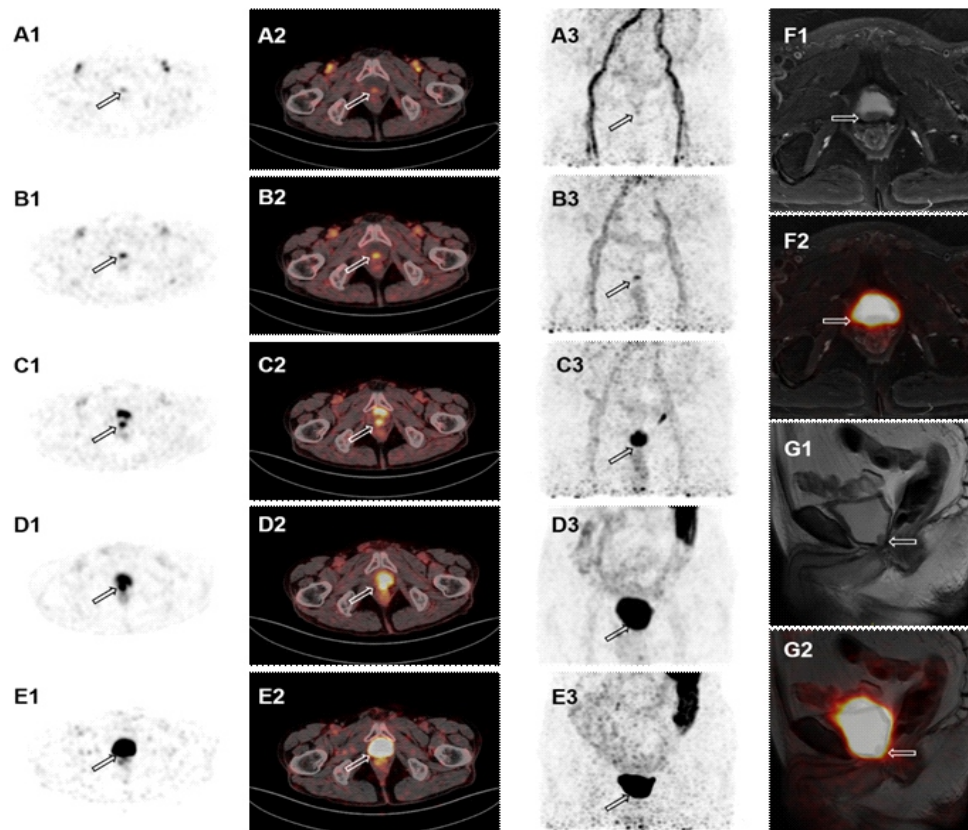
A 79-year-old man with prostate cancer was treated with prostatectomy. He presented with a rising PSA level of 6.00ng/mL. Thus, ^{68}Ga -PSMA-11 PET/CT was performed for possible recurrence lesions. Due to early PET imaging increases the detection rate of local recurrence for patients with patients with biochemical recurrence, dynamic imaging (immediately postinjection, 10 frames, 60s each), routine PET/CT scans (60min postinjection) and delayed image (3h postinjection) were performed. The dynamic imaging at the early stage (A1-A3, 60s postinjection; B1-B3, 5min postinjection; C1-C3, 10min postinjection) showed avid PSMA uptake in the posterior wall of the urinary bladder. As time goes on, this lesion was difficult to distinguish because of adjacent physiological urine activity on routine imaging (D1-D3) and delayed imaging (E1-E3). For the sake of further evaluation, PSMA PET/MR was performed. Pelvic MRI (F1; G1) showed a soft tissue nodule in the posterior wall of the urinary bladder on the T2WI image. This lesion had iso-intensity (relative to muscle). Similarly, fusion image also can not differentiate uptake degree for urine activity interference (F2, G2). According to the joint EANM and SNMMI procedure guidelines, routine ^{68}Ga -PSMA-11 PET/CT scans are recommended to be acquired 1h after injection [1]. It is reported that ^{68}Ga -PSMA-11 PET/CT has no advantage in detecting local lesions in close anatomical relation to the bladder [2]. Increased lesion detection rate in close proximity to the ureter or the bladder has been reported with delayed imaging up to 3-4 hours post injection [3]. Our case indicates early dynamic scan is conducive to increasing the rate of detected lesions, especially for the existence of adjacent physiological urine activity disturbance lesions [4].
